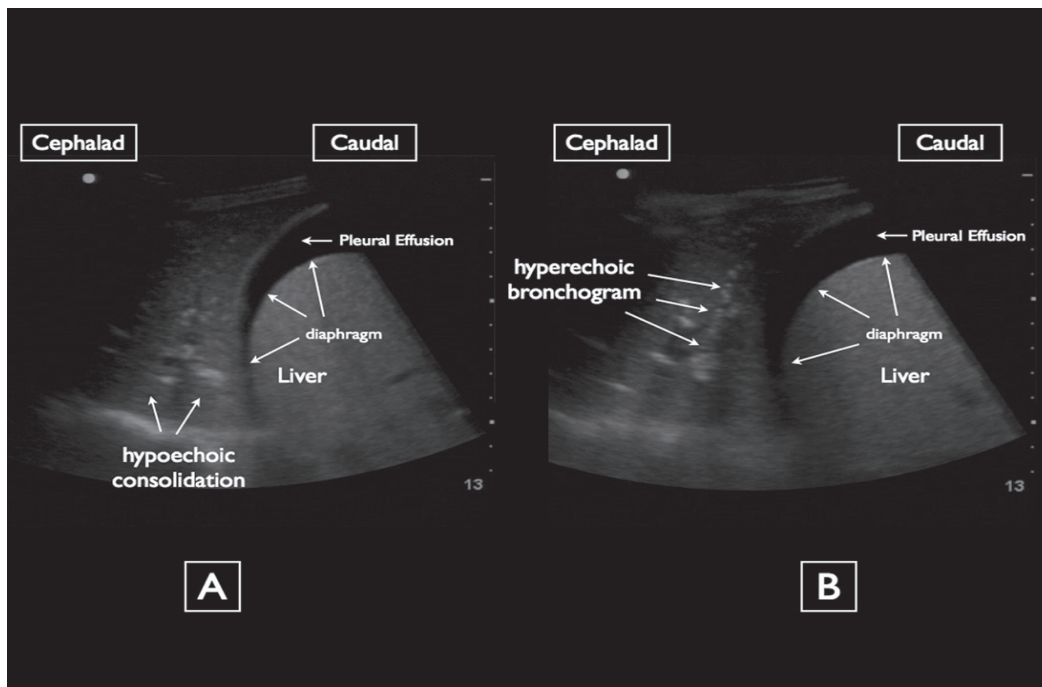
A) Ultrasound of the right lower thorax. B) Ultrasound of the right lower thorax.
